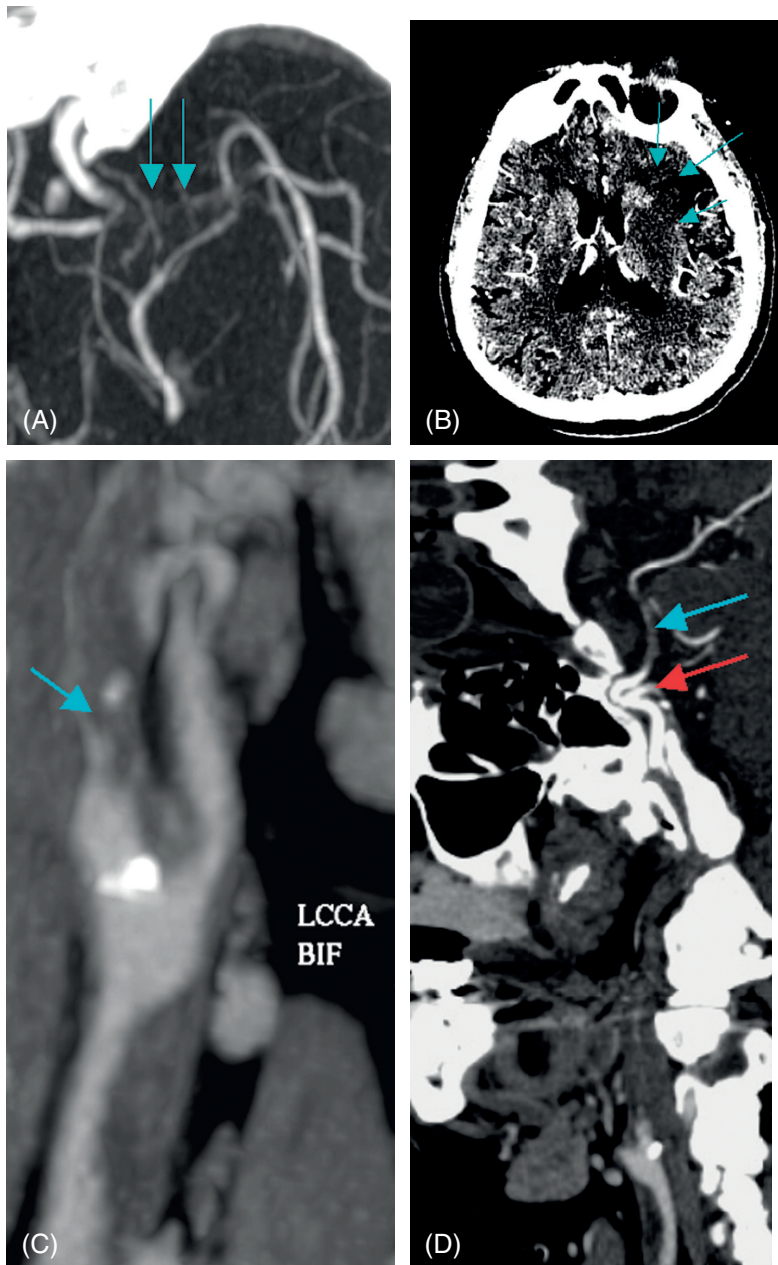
CTA of the head and neck and CTA-SI analysis: Left proximal middle cerebral artery segmental occlusion is demonstrated on head CTA (A, arrows). Hypoperfused and possibly ischemic brain tissue is most conspicuous on CTA source images (CTA-SI) as hypo-attenuated region (B, arrows). Maximum-intensity projection of the carotid bifurcation demonstrates source of embolic infarct with clot occluding the proximal left internal carotid artery (C, arrow). CR view demonstrates absence of flow through the occluded cervical internal carotid artery, reconstitution of flow within the cavernous/supraclinoid carotid segments (D, red arrow) and again more distal obstruction of proximal middle cerebral artery segment (D, blue arrow).
